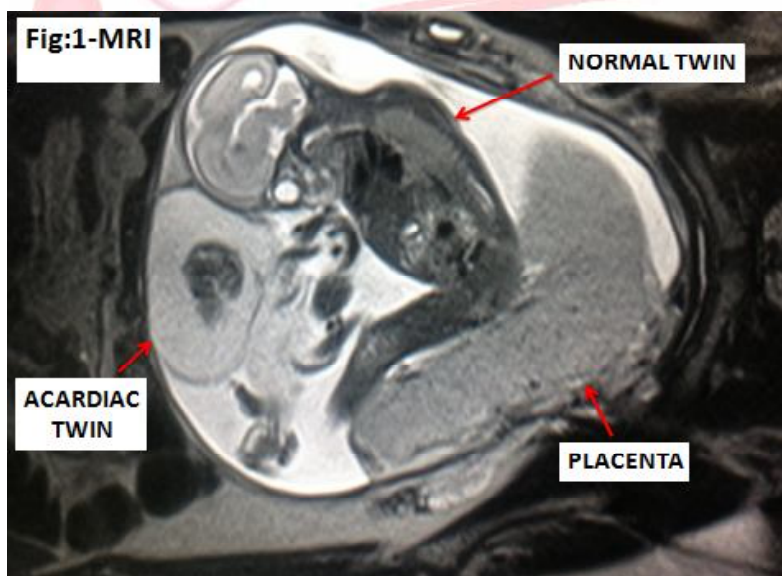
MRI Scan Showing Twin Reversed Arterial Perfusion Sequence (TRAP sequence).
